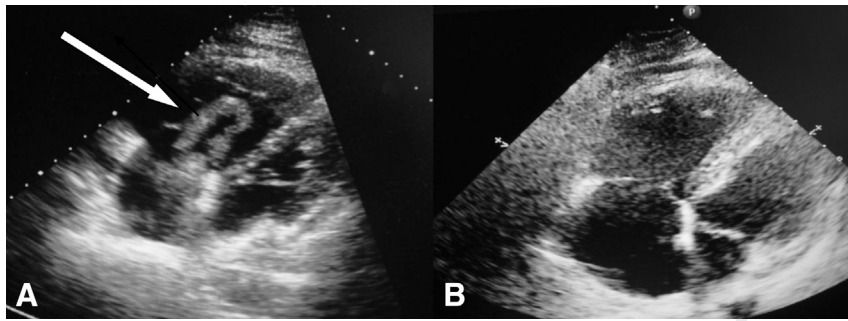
(A) Initial bedside cardiac ultrasound demonstrating a serpiginous mass in the right atrium and right ventricle. (B) Transthoracic echocardiogram done 6 h after the administration of thrombolytics demonstrating complete resolution of right heart thrombus in transit.
